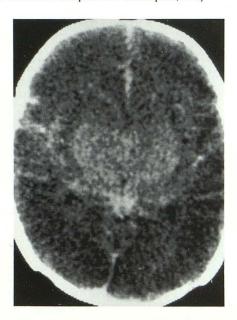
Diffuse H-I injury in a 1-day-old infant. Axial noncontrast CT shows complete obliteration of ventricular, sulcal, and cisternal cerebrospinal fluid spaces, a loss of the gray/white differentiation between cortex and subjacent white matter, and preservation of the density in the central ganglionic structures.
